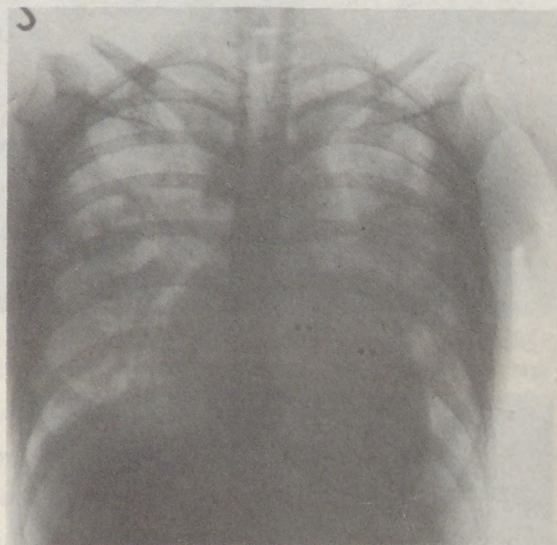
Thoracic X-ray picture of M.J. (case 2) on admission
